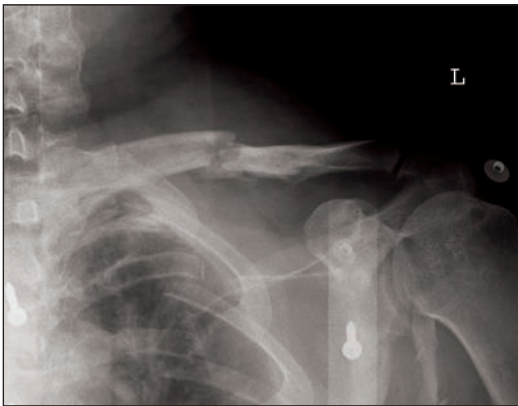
Clavicle x-ray.
